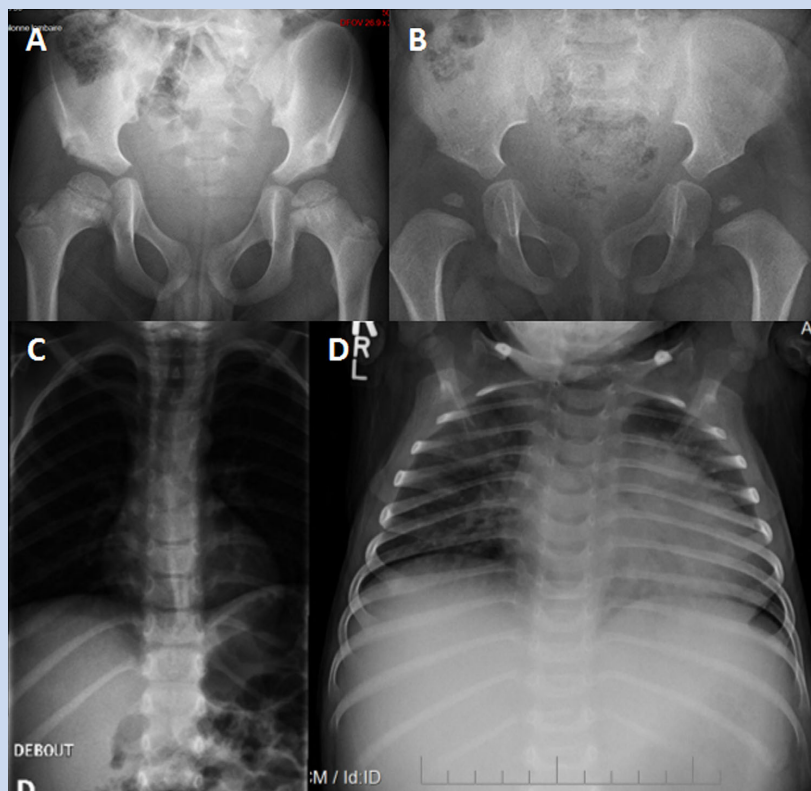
Radiographs of the pelvis and chest in patients with NBAS deficiency. A) Pelvis of patient 1 at age 7 years and 10 months: the capital femoral epiphyses are mildly flattened; there are metaphyseal irregularities at the proximal femur, bilaterally. B) Pelvis of patient 2 at age 2 years; note small capital femoral epiphyses. C) Chest radiograph of patient 1 at age 7 years; note thin ribs and normal vertebral bodies. D) Chest radiograph of patient 2 at age 2 years; note short twelfth rib.
